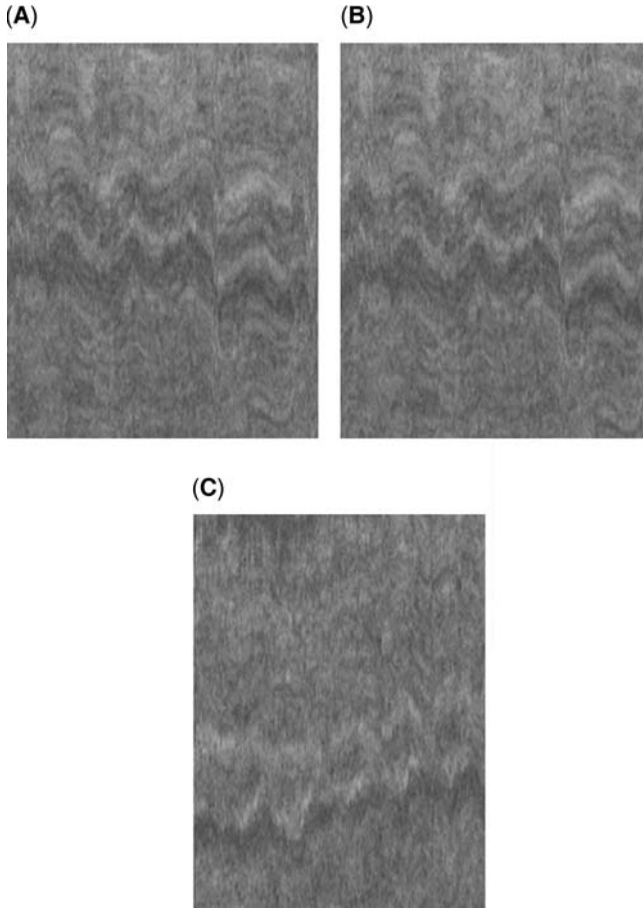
Ultrasound-based motion analysis images (A–C) of 1.5 minutes in duration, showing individual women with slow (A: 3 contractions per minute), medium (B: 5 contractions per minute), and fast (C: 7.5 contractions per minute). The amplitude and frequency of the contractions are easily visualized. *Source:* From Ref. 159.
